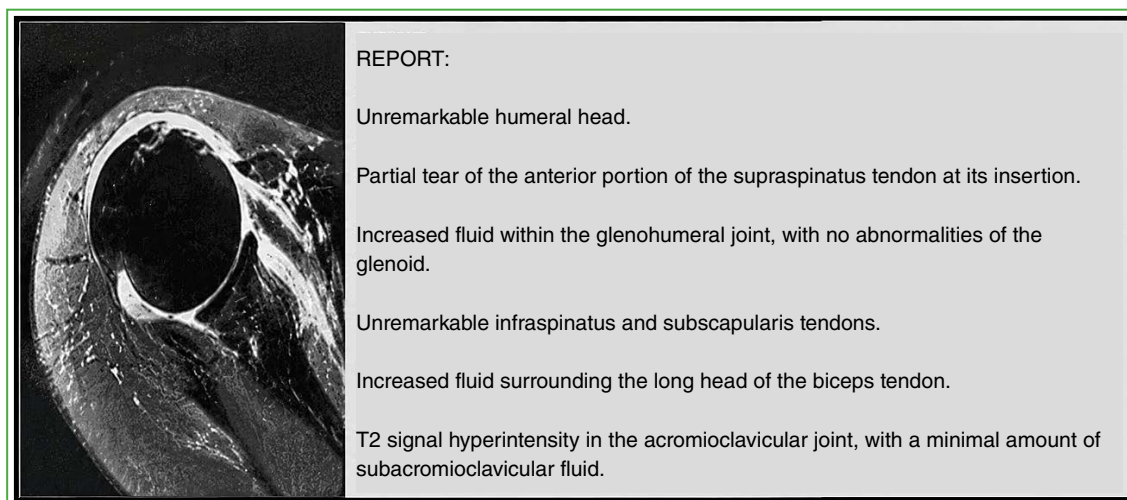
MRI study in which the report states that the subscapularis muscle shows no abnormalities, despite the presence of a full-thickness tear of its distal insertional tendon.
